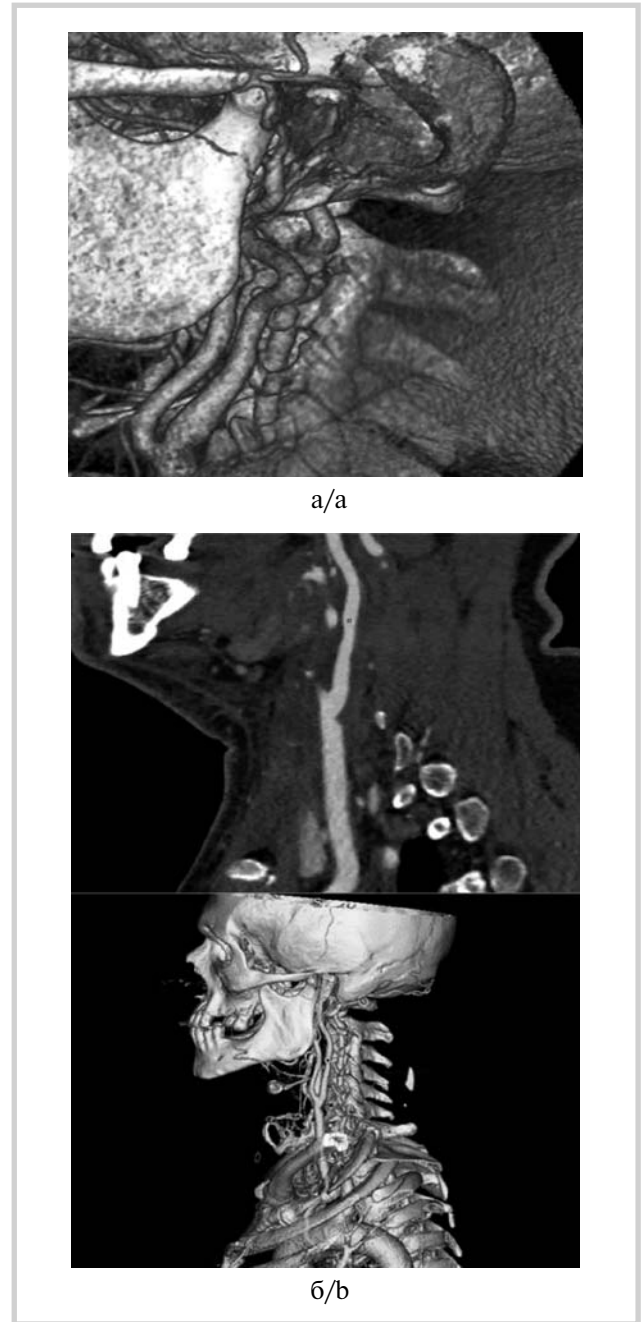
CT angiography of a 47-year-old patient.
